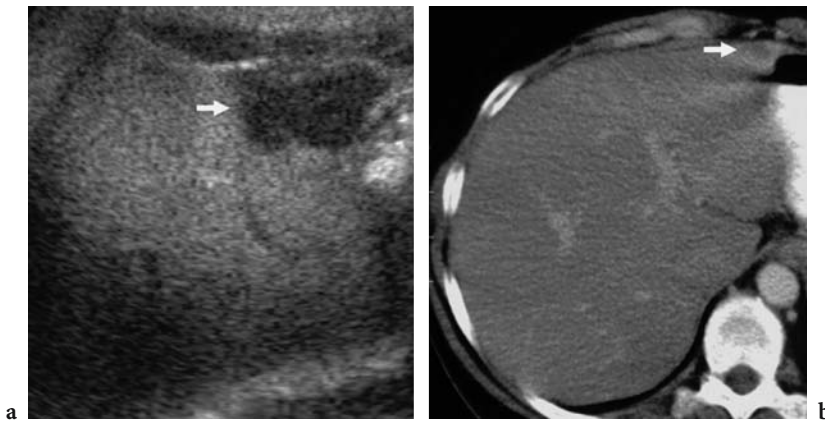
Improved detection of metastatic lesions by contrast-enhanced US in comparison with contrast-enhanced CT. Contrast-enhanced US (a) after the injection of air-filled microbubbles, with high acoustic power. A single metastasis is identified in the anterior region of the left liver lobe. This lesion (*arrow*) was identified only retrospectively on contrast material-enhanced CT (b).
